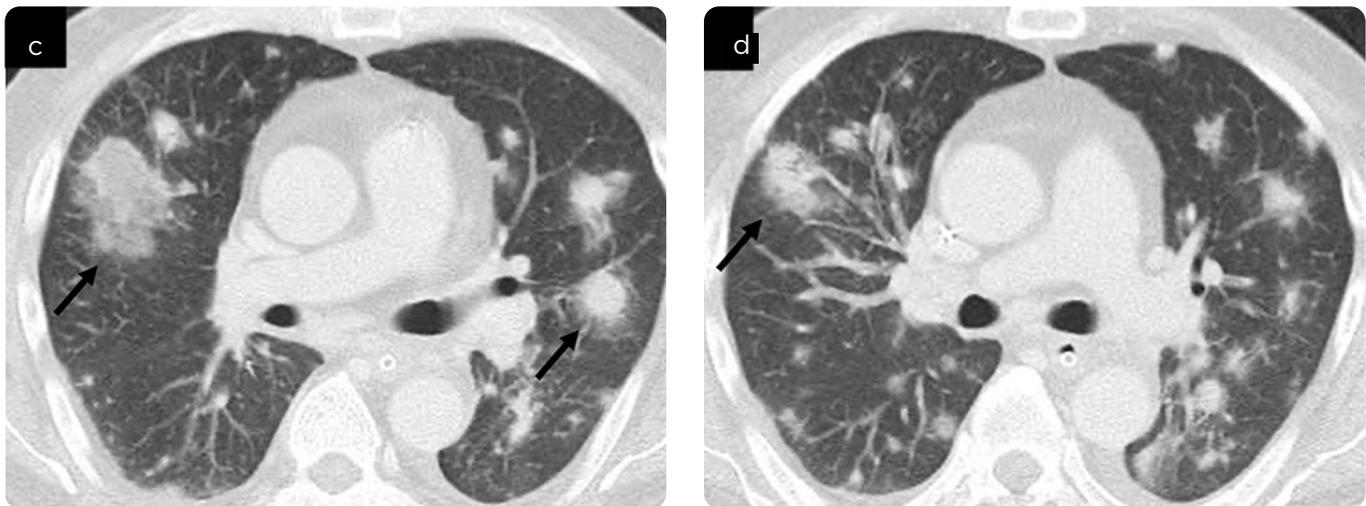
Patient with history of infection by human immunodeficiency virus. a and b) CT, axial section, in lung window. Some nodular opacities and masses of partially defined contours with “ground glass” halo distributed in the different pulmonary segments are observed in a patient with known diagnosis of Kaposi’s sarcoma.
